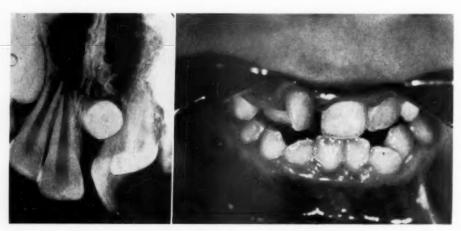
X-ray showing the supernumerary tooth, and photograph of the produced anomaly.
